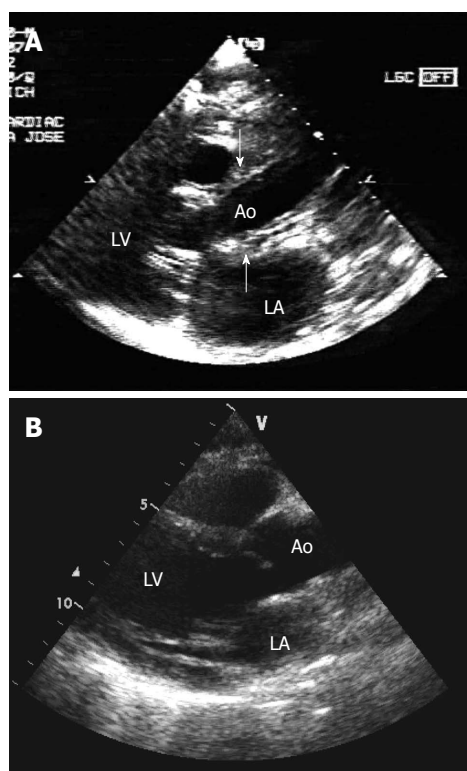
Two-dimensional echocardiography - parasternal long-axis view. A: Before chemotherapy, the echocardiogram showed tumor infiltration of the aorta (see arrows). B: After chemotherapy, the echocardiogram showed total regression of aortic infiltration. LA: Left atrium; LV: Left ventricle; Ao: Aorta.
